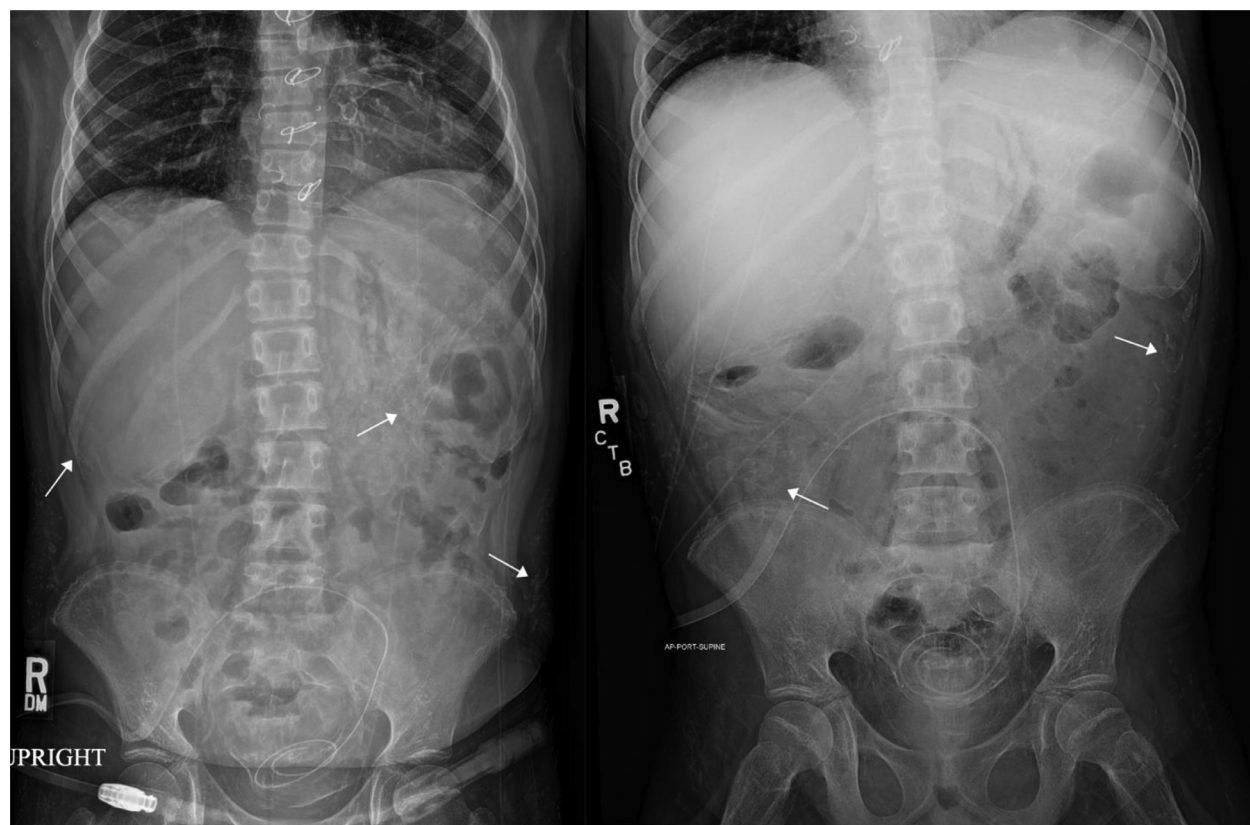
Abdominal radiographs demonstrate a nonobstructive bowel gas pattern with diffuse curvilinear hyperdensities in the abdomen and pelvis compatible with calcifications (arrows). A peritoneal dialysis catheter is seen coiling in the lower abdomen.
